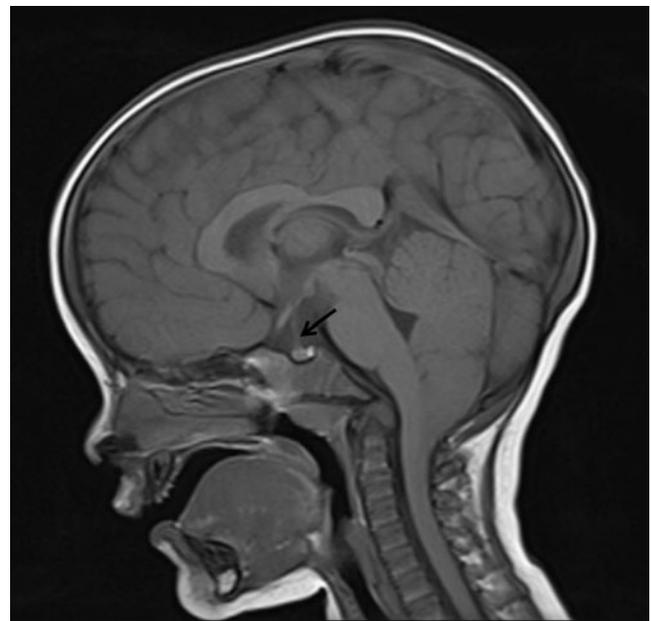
Sagittal T1-weighted MRI in a patient with a prefixed optic chiasm. Note the more anteriorly positioned pituitary stalk (*arrow*)
